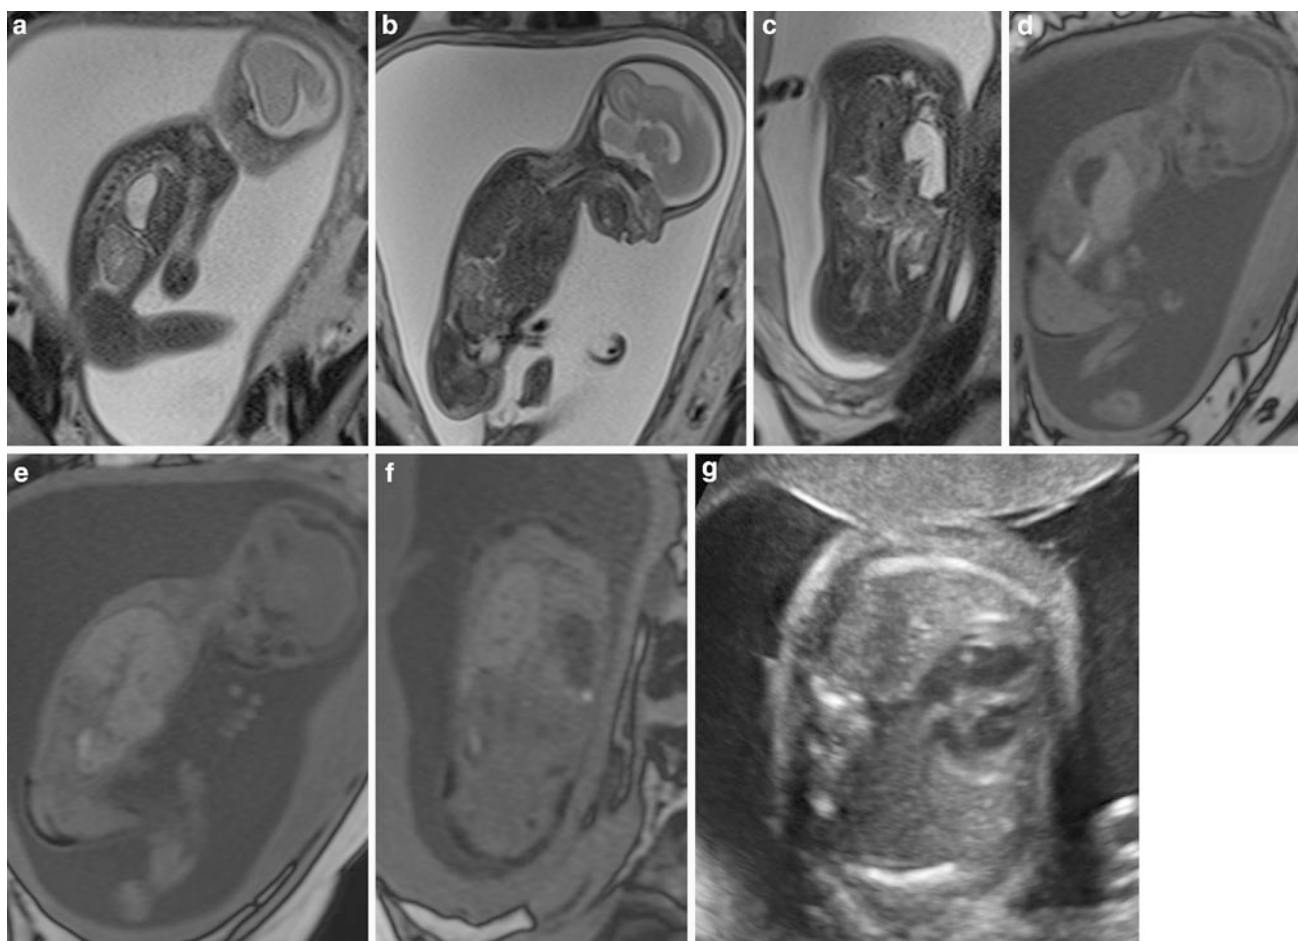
Diaphragmatic hernia. a–c Coronal and axial T2-weighted views showing a left diaphragmatic hernia. Note a small stomach and multiple bowel loops in the left hemithorax displacing the heart to the right side (*arrowheads* in b). The liver maintained the abdominal position and the right lung present normal signal intensity. d Sagittal
